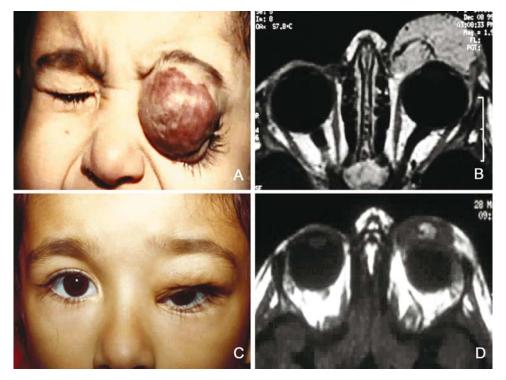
(A) Facial photograph demonstrating nonregressing extensive left eyelid capillary hemangioma in a 3-yearold girl after several corticosteroid injections. (B) T1-weighted, contrast-enhanced axial orbital MR image showing the hyperintense capillary hemangioma. Note the signal-void high-flow vessels in the lesion. (C) Facial photograph after alfa-2b interferon treatment showing marked regression of the lesion at 1-year follow-up. (D) T1-weighted axial orbital MR image at 1-year follow-up demonstrating the marked resolution of the capillary hemangioma. The tumor is isointense to slightly hyperintense to the extraocular muscle and cerebral gray matter.
